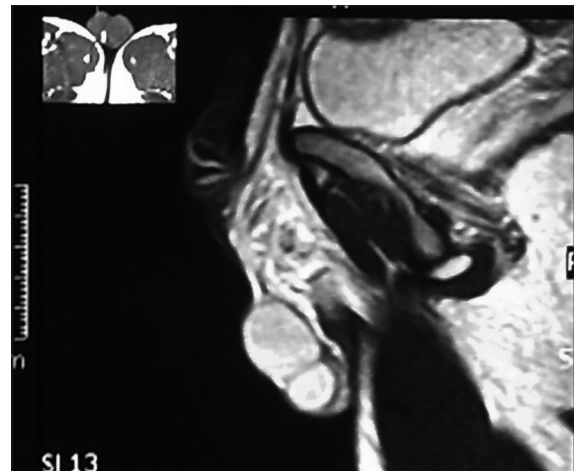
Sagittal T2-weighted image showed a mass with the same signal features as the normal testicles
